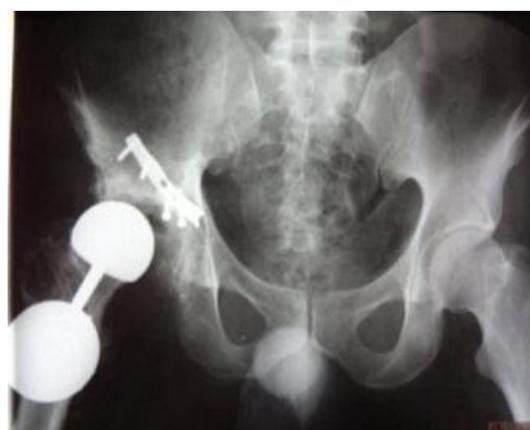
Plain x-ray AP view showing both hip with resurfacing of right hip. RT acetabulum Posterior wall and roof defect fixed by plate and screw.
